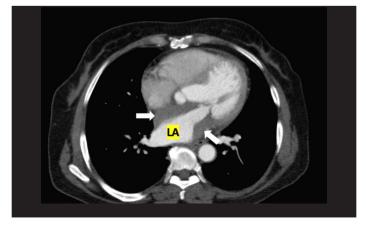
Increased thickness narrowing the left atrial lumen was observed in thorax computed tomography (white arrow) (LA: Left Atrium)
